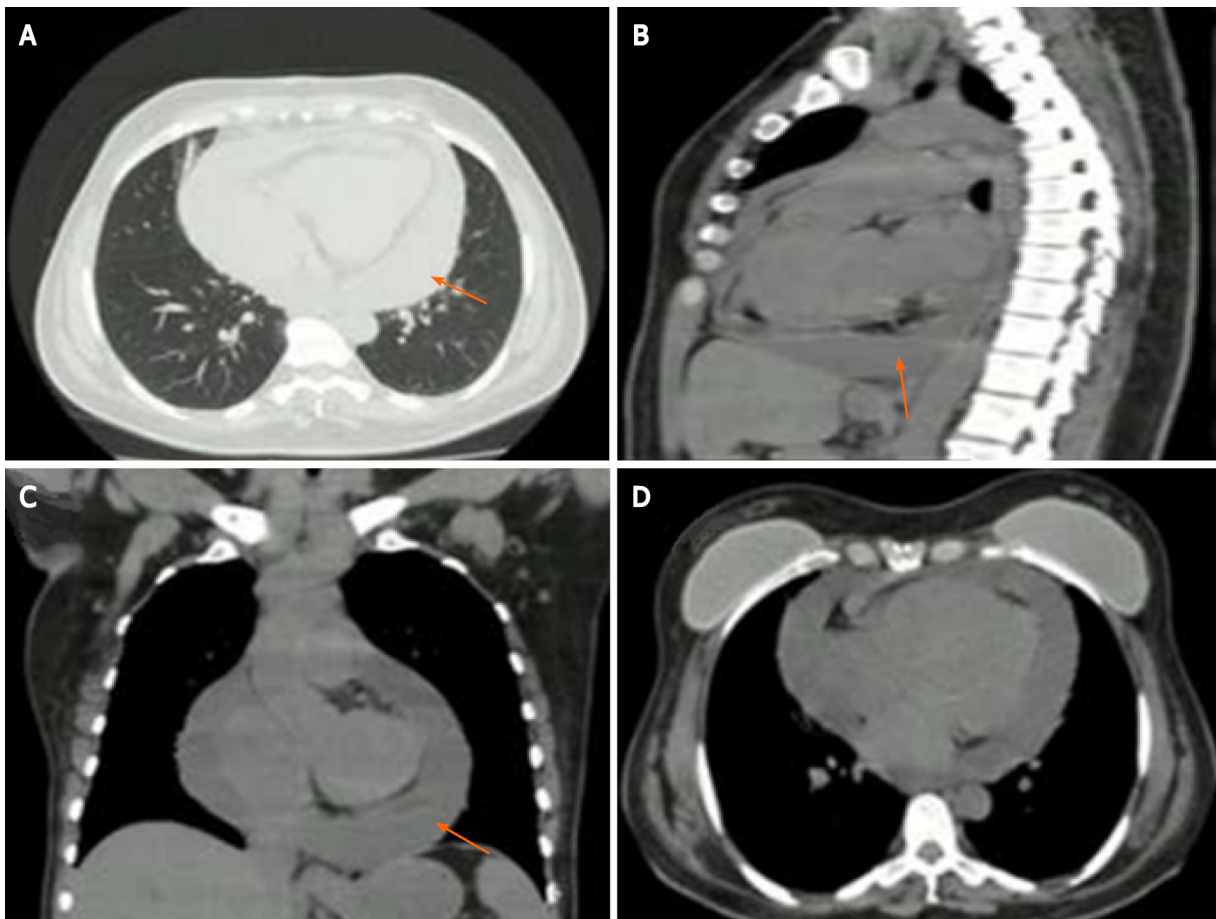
Chest computed tomography. A-C: Axial (A), sagittal (B), and coronal (C) computed tomography showing severe pericardial effusion thickness of up to 25 mm (arrows); D: No evidence of right ventricular free wall flattening. The breast implants had no signs of extracapsular rupture.
